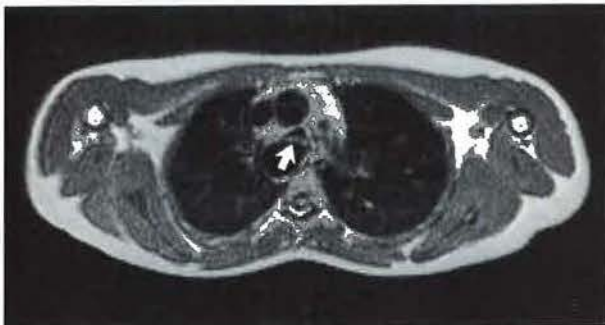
Magnetic resonance images: (upper panel) axial plane; and (lower panel) sagittal plane. Note that the trachea (arrow) is compressed between the ascending and descending aorta.
